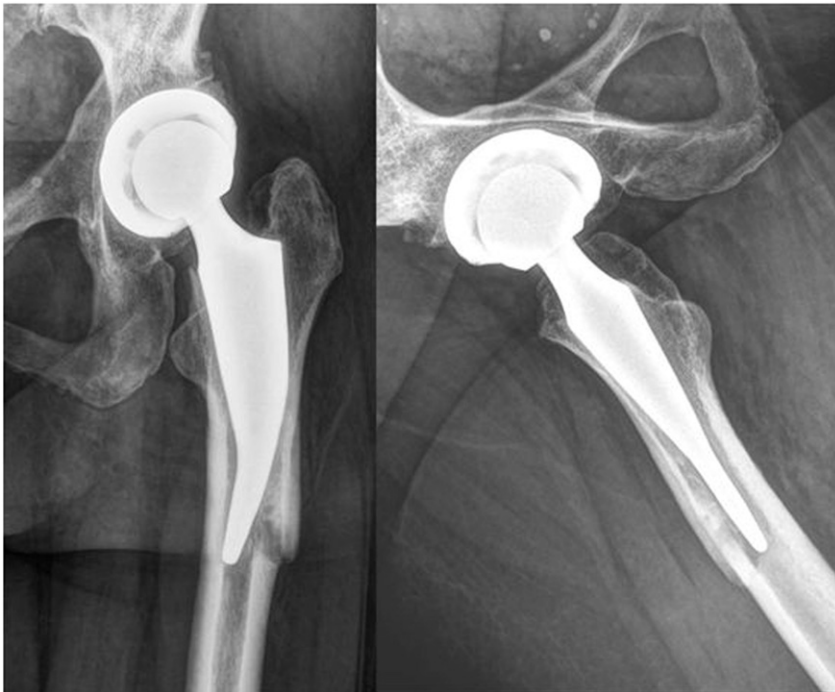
a: Radiograph taken 6 months postoperatively, showing a consolidated fracture on the AP view without subsidence if compared with postoperative image (Fig. 2b). b: Lateral view 6 months postoperatively showing a well positioned stem.
